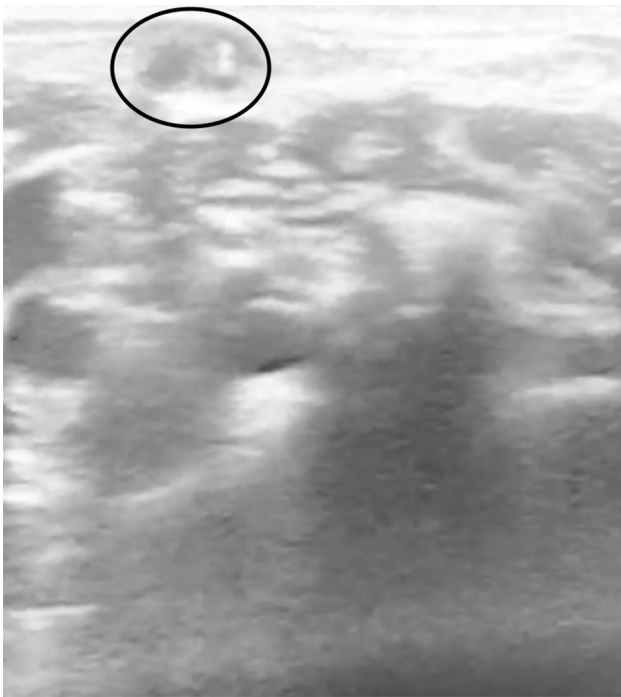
The ultrasonographic view of the external jugular vein and the fractured cannulas within the lumen of the vein.
